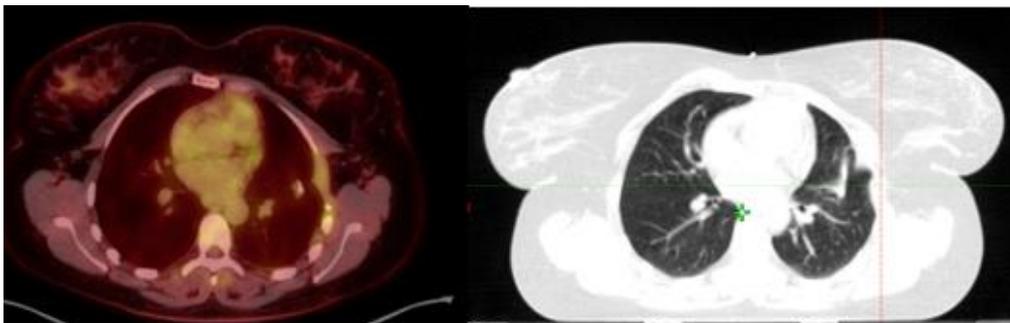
Postoperative PET/CT and CT- Without data on residual tumor tissue, as well as data on lymphogenic and hematogenous dissemination
